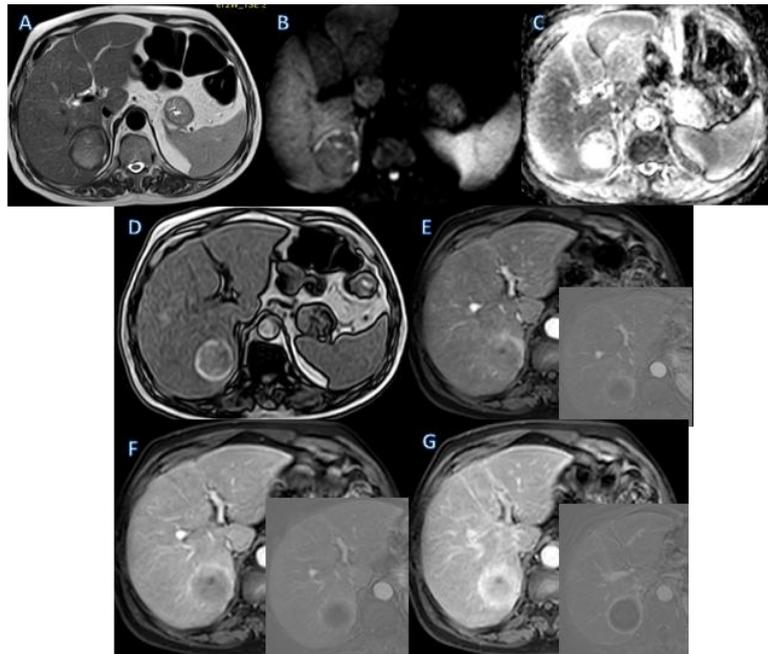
Figures from A to H showing cirrhotic liver with well ablated segment VII HCC. A: T2 WI showing high signal intensity. B: DWI eliciting low signal of the HFL with peripheral foci of high signal. C: ADC eliciting high signal of the HFL (ADC value 1256×10^{-3}) with peripheral foci of low signal (ADC value 930×10^{-3}) D: T1 WI out of phase eliciting isointense signal of the HFL with peripheral hyperintense rim. E to G: Post contrast dynamic images in late arterial (E), Venous (F) and delayed (G) phases with subtraction images showing no intralesional post contrast enhancement with peripheral arterial contrast enhancement persistent in portovenous and delayed phases likely representing fibrosis.
